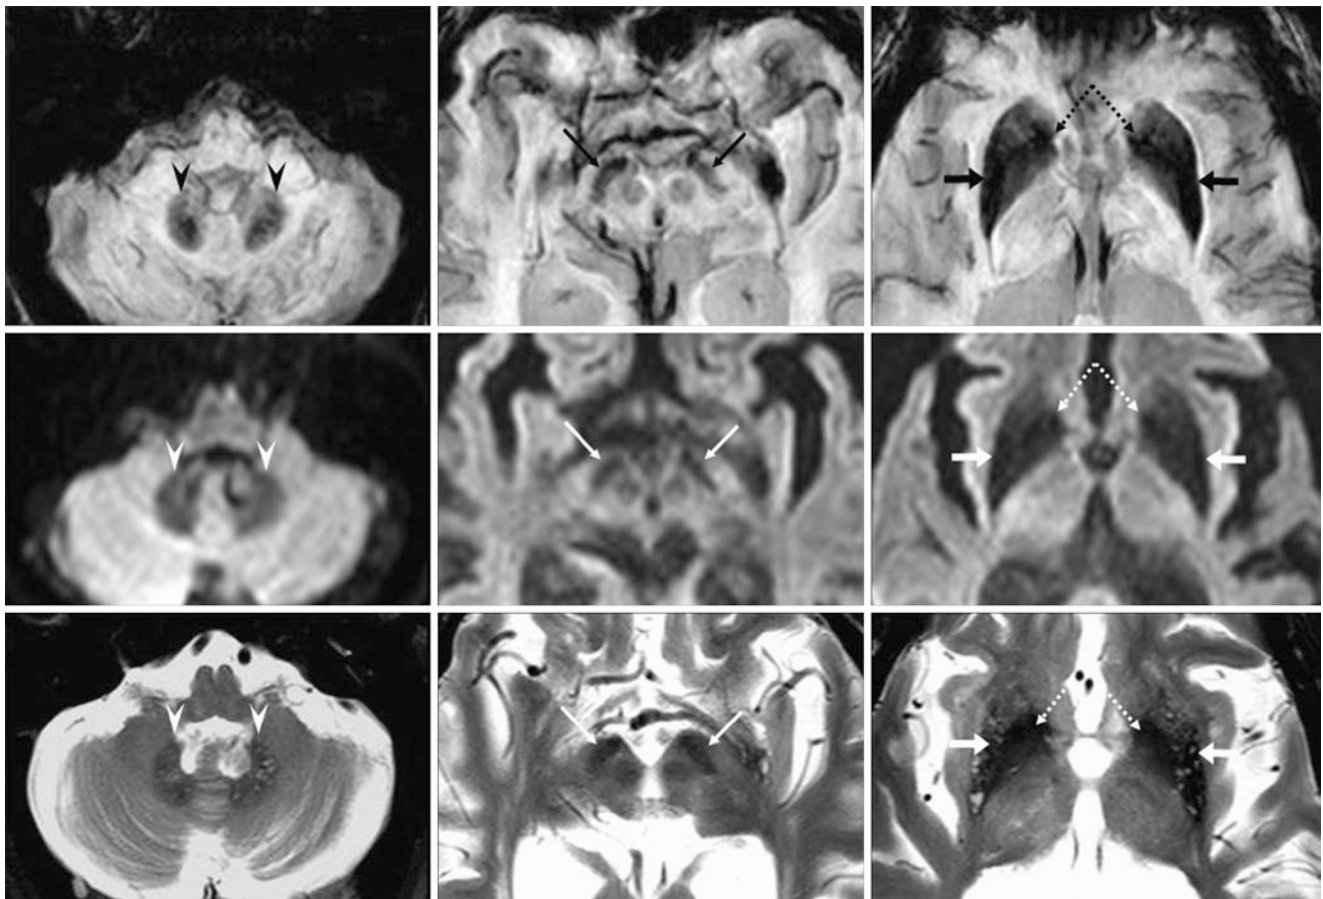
A 91 year old with a negative 3T MRI performed for altered mental status. *Top row:* SWIs show iron deposition of the dentate nuclei (*arrowheads*), SN (*thin arrows*), and GP (*dotted arrows*). Both the GP and lentiform nuclei have become homogeneously dark
